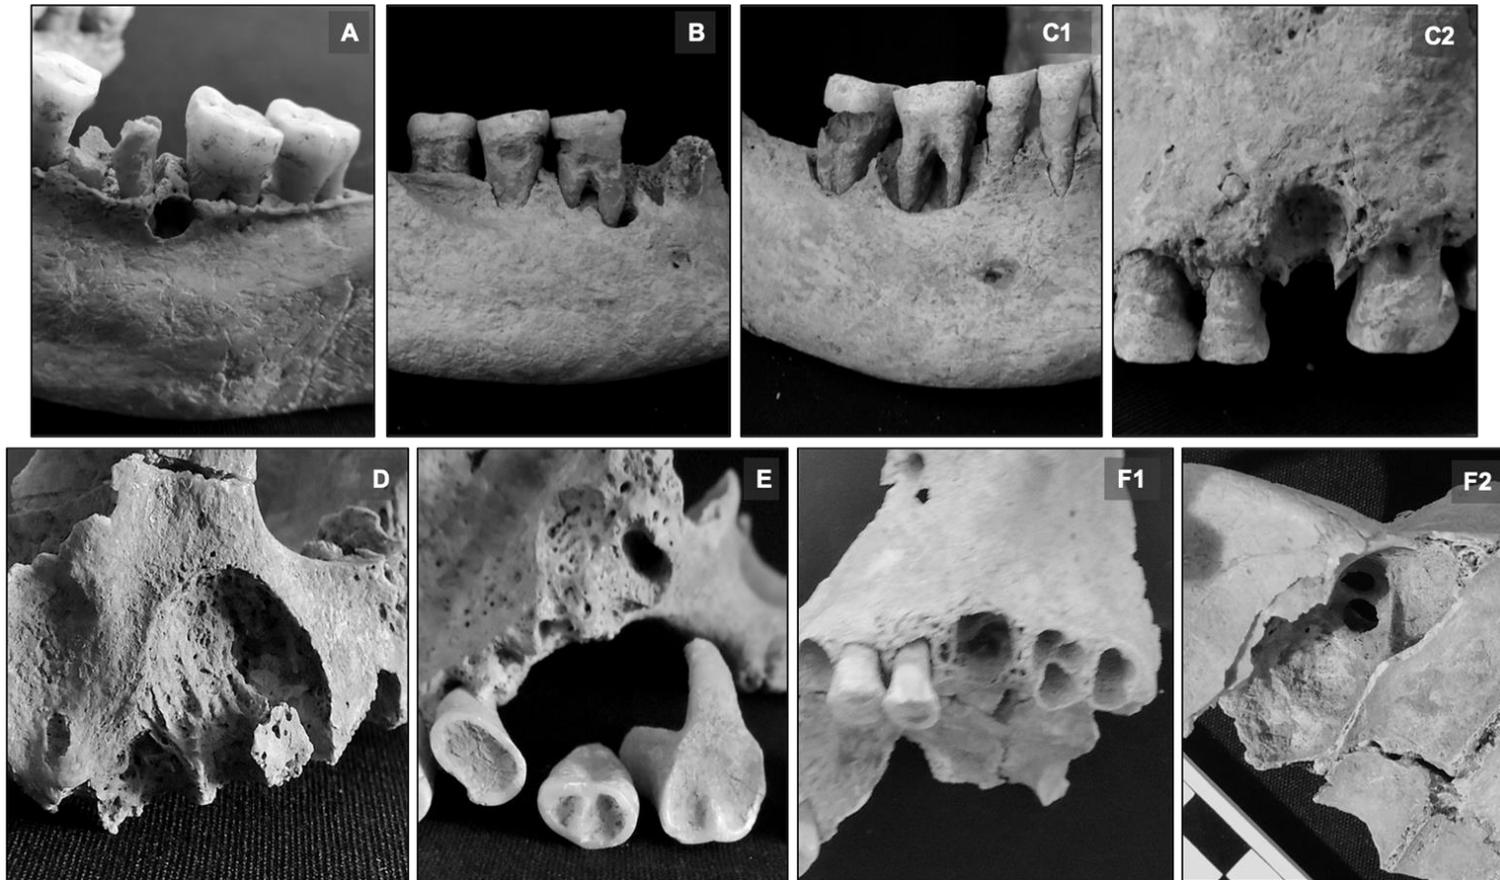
Examples of dental abscesses at Ostojićevo: (A) Left-M1 “periapical” abscess in Grave 166, an -Adult female; (B) “Periapical” abscess in Grave 154, an Adult II female; Right-M1 and M2 (C1) and left-M1 (C2) “continuous” abscess in Grave 203, an Adult IV female; (D) Right-I2 to P1 large “continuous” abscess in Grave 199, an Adult III male; (E) Right-M1 “complex-continuous” abscess consistent with a nonapical periodontal abscess of pulpal origin in Grave 220, an Adult female; Facial view (F1) and view from maxillary sinus (F2) of a left-M1 “complex-periapical” abscess in Grave 256, an Adult II female.
